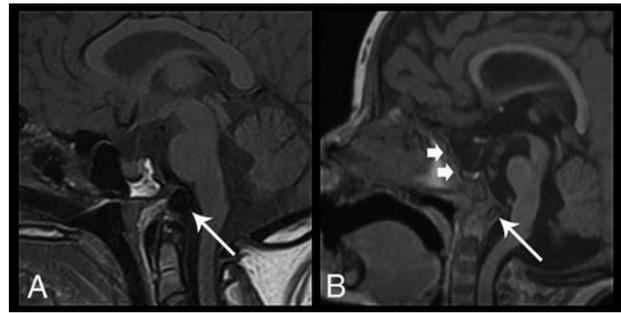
Sagittal images of skull base dysplasia in 2 different patients. A, Sagittal T1-weighted image demonstrates skull base hypoplasia with dorsal angulation and posterior displacement of a hypoplastic basioccipital ossification center (arrow) and widening of the sphenoccipital synchondrosis. B, Sagittal 3D T1-weighted image shows a J-shaped sella (short arrows) with flattening and elongation of the tuberculum sellae. There is also evidence of a dorsally angulated clivus (long arrow), with findings similar to those in A. None of the patients had basilar invagination.
